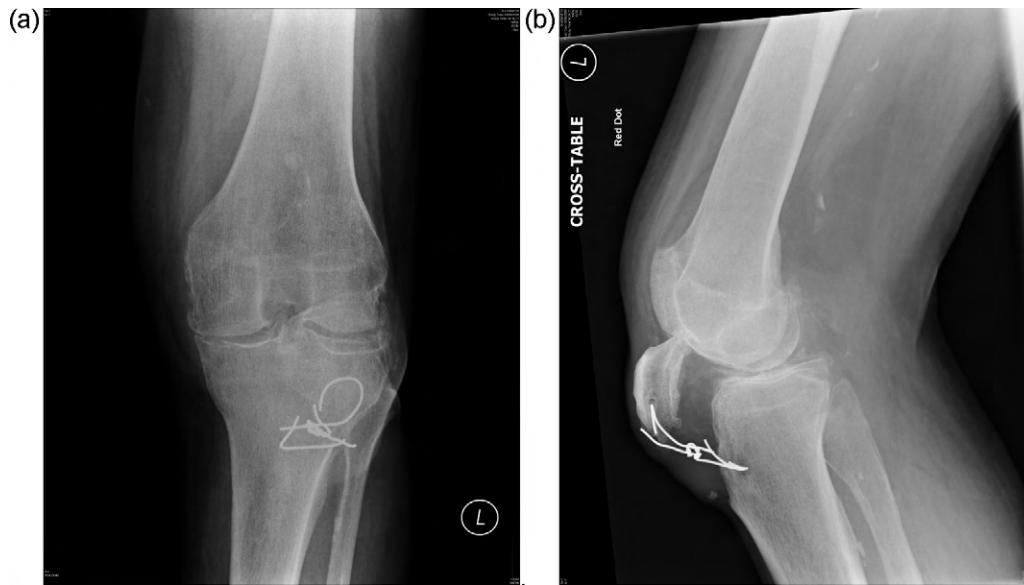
Initial post-traumatic (a) anteroposterior and (b) lateral radiographs; showing impaction of the patella under the lateral femoral condyle and previous wire fixation of the patella ligament.
